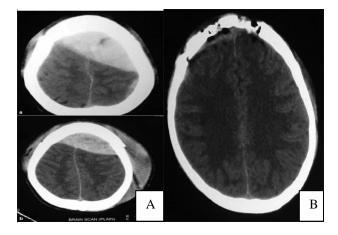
Postoperative and preoperative CT scan brain of case 2.
